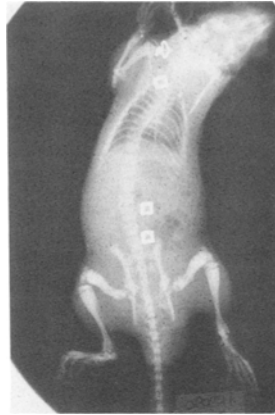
Radiograph 50 days after treatment of a thymectomized op/op mutant that received subcutaneous and intraperitoneal thymic grafts at the age of 21 days. The skeleton remained osteopetrotic.
